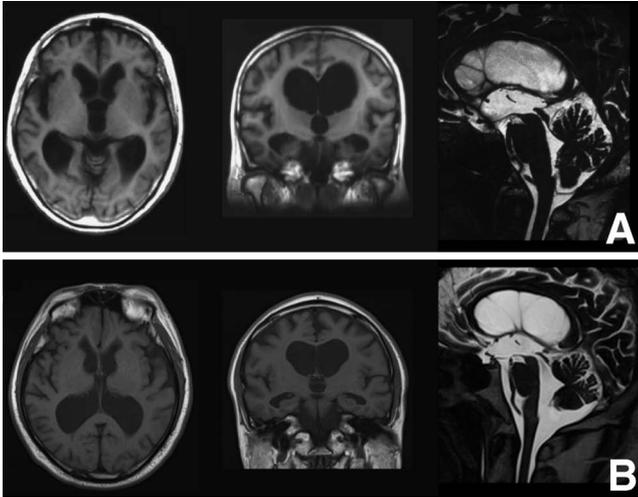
Magnetic resonance imaging features of disproportionately enlarged subarachnoid space hydrocephalus. The features include tight high convexity and medial subarachnoid spaces and enlarged sylvian fissure associated with ventriculomegaly. Cerebrospinal fluid is distributed disproportionately between the superior and inferior subarachnoid spaces.
